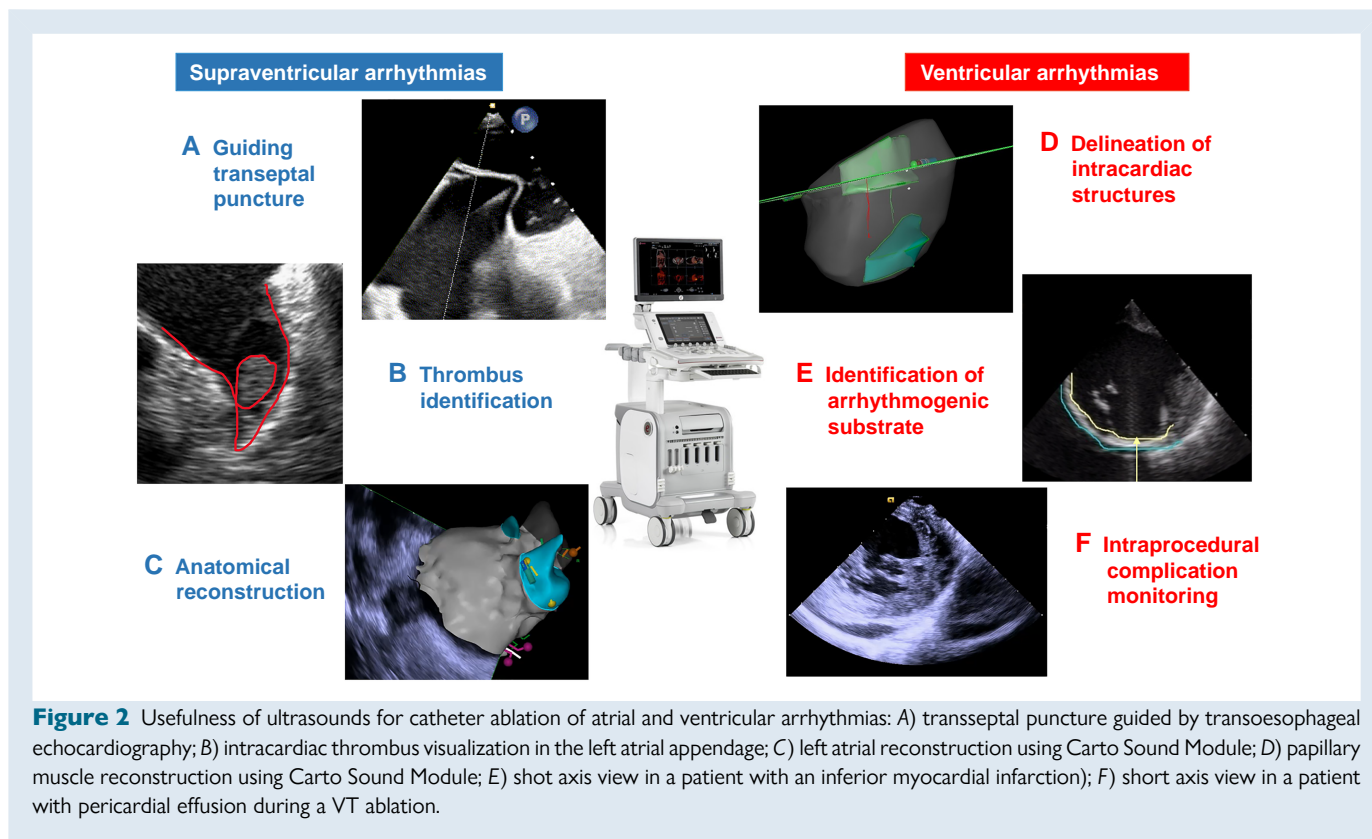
Usefulness of ultrasounds for catheter ablation of atrial and ventricular arrhythmias: A) transeptal puncture guided by transoesophageal echocardiography; B) intracardiac thrombus visualization in the left atrial appendage; C) left atrial reconstruction using Carto Sound Module; D) papillary muscle reconstruction using Carto Sound Module; E) shot axis view in a patient with an inferior myocardial infarction; F) short axis view in a patient with pericardial effusion during a VT ablation.
